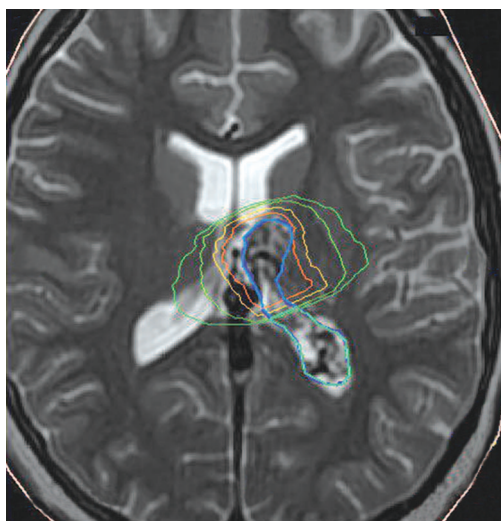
Planning magnetic resonance imaging scan for stereotactic radiosurgery of a 13-year-old girl who presented with intraventricular hemorrhage. Note that the 1500-cGy isodose line extends significantly into the thalamus despite conformal target planning with multileaf collimators, primarily because of the irregular shape of the AVM.
